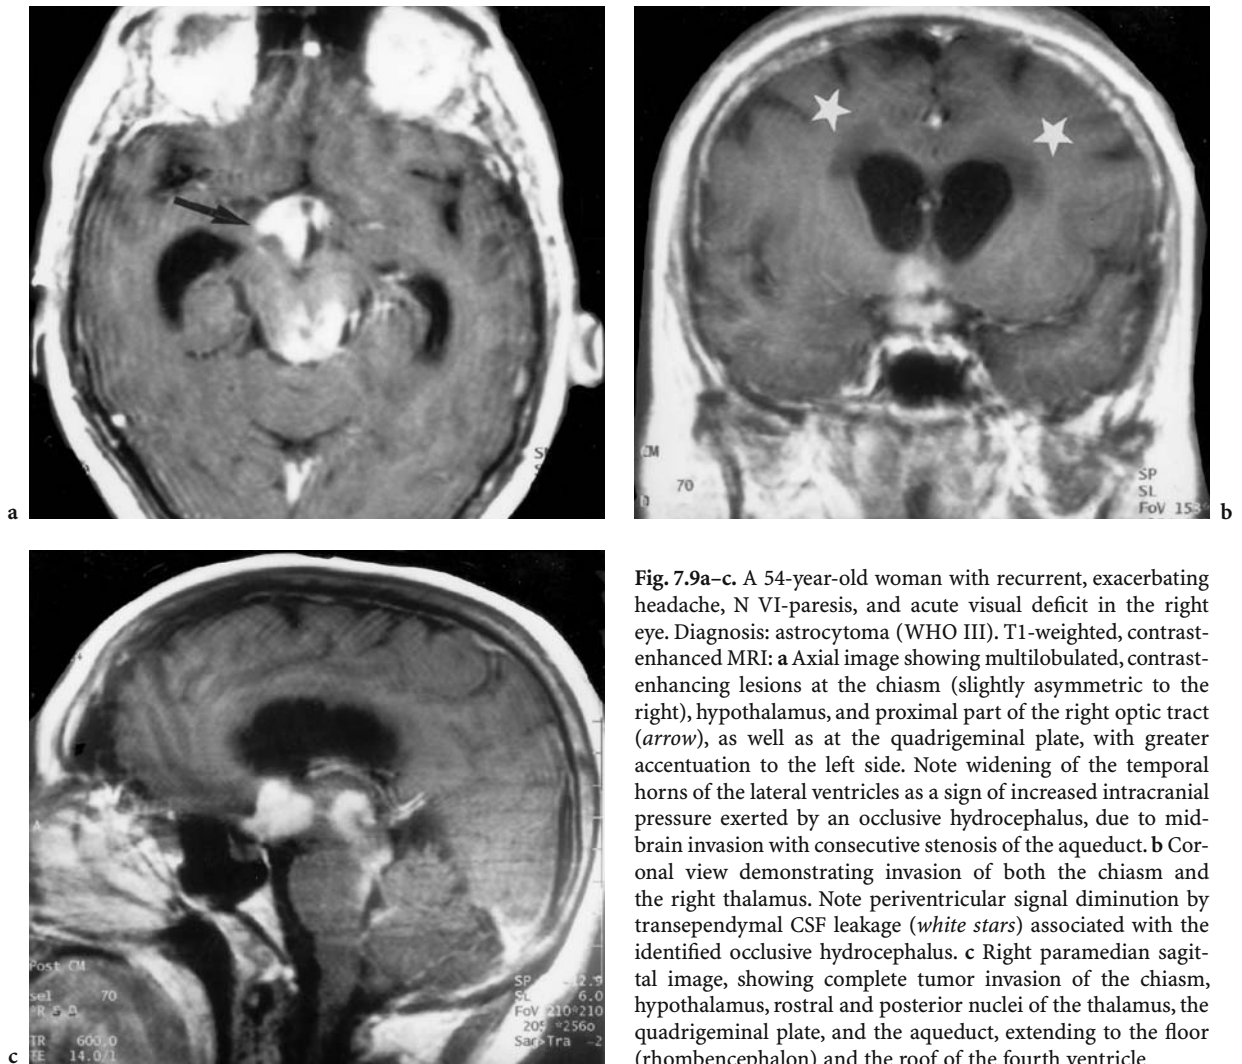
A 54-year-old woman with recurrent, exacerbating headache, N VI-paresis, and acute visual deficit in the right eye. Diagnosis: astrocytoma (WHO III). T1-weighted, contrast-enhanced MRI: a Axial image showing multilobulated, contrast-enhancing lesions at the chiasm (slightly asymmetric to the right), hypothalamus, and proximal part of the right optic tract (*arrow*), as well as at the quadrigeminal plate, with greater accentuation to the left side. Note widening of the temporal horns of the lateral ventricles as a sign of increased intracranial pressure exerted by an occlusive hydrocephalus, due to mid-brain invasion with consecutive stenosis of the aqueduct. b Coronal view demonstrating invasion of both the chiasm and the right thalamus. Note periventricular signal diminution by transpendymal CSF leakage (*white stars*) associated with the identified occlusive hydrocephalus. c Right paramedian sagittal image, showing complete tumor invasion of the chiasm, hypothalamus, rostral and posterior nuclei of the thalamus, the quadrigeminal plate, and the aqueduct, extending to the floor (rhombencephalon) and the roof of the fourth ventricle
